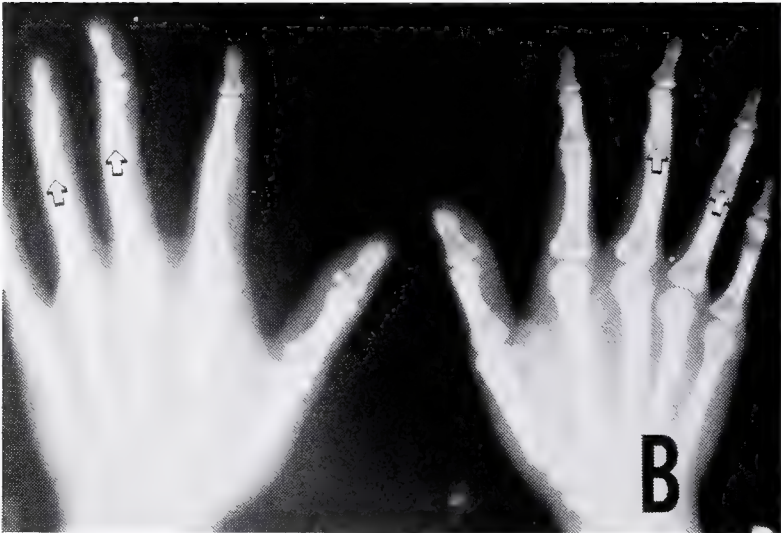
X-ray appearance of symphalangism in an adult male showing complete fusion of the PIP joints of the middle, ring and little fingers. The index and thumb are normal.
